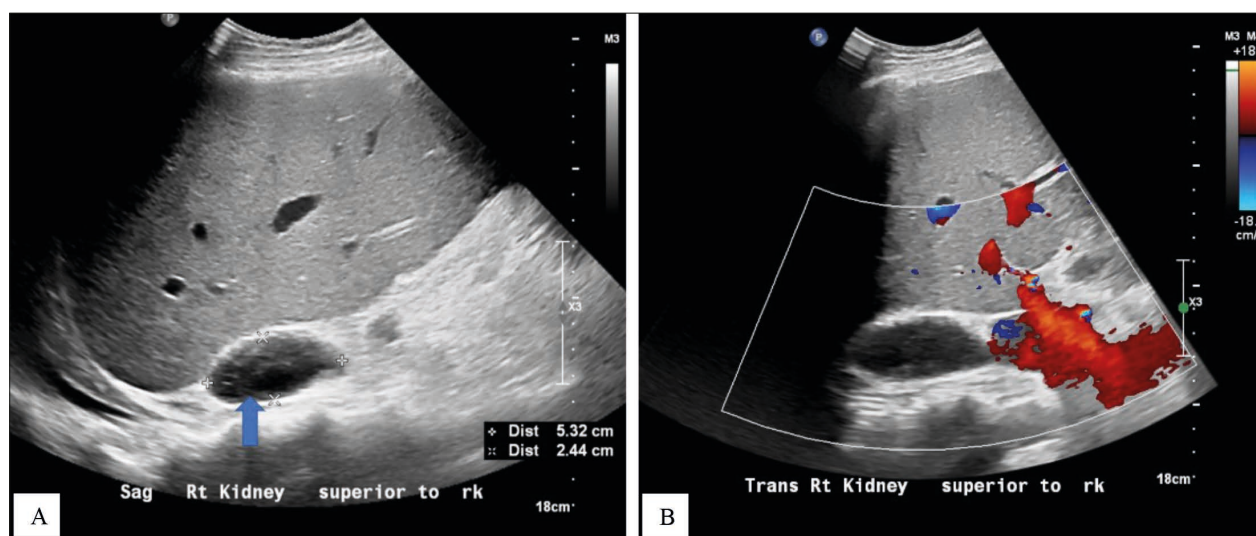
The abdominal ultrasound with the blue arrow (A) shows a hypoechoic structure at the level of the right adrenal gland with no vascularization on color images (B) and likely corresponding with bilateral adrenal hemorrhage.
